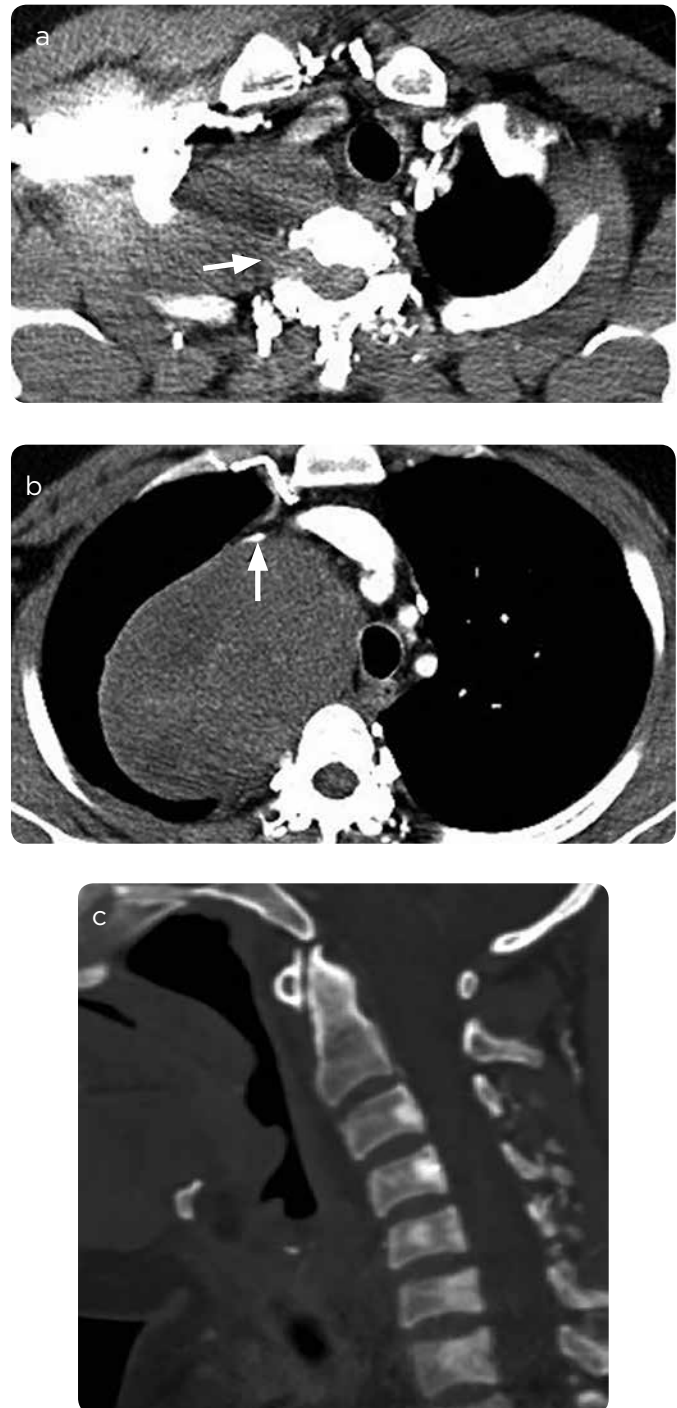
Chest CT with contrast medium. a and b) Mediastinum window: A well-defined mass of the posterior mediastinum invading the right root emergency foramen T1-T2 (arrow in a) and the central canal. It contacts the right lateral wall of the trachea by moving it to the left and the visceral pleura at the ipsilateral apex. It contacts and displaces the superior vena cava previously, causing a decrease in its calibre (arrow in b). c) Sagittal CT reconstruction of the neck in the bone window: Blast lesions in the vertebral bodies from C3 to T1.
